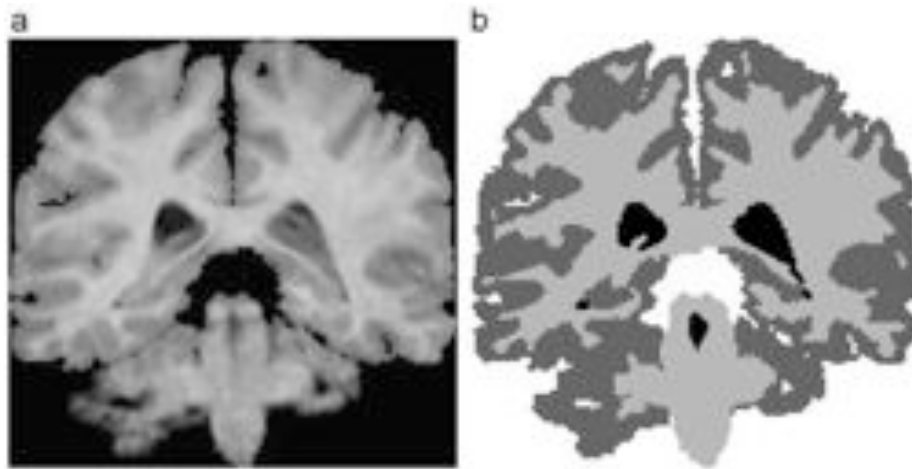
(a) Original T1-weighted coronal slice from a volume in the IBSR collection and (b) its corresponding manual segmentation.
